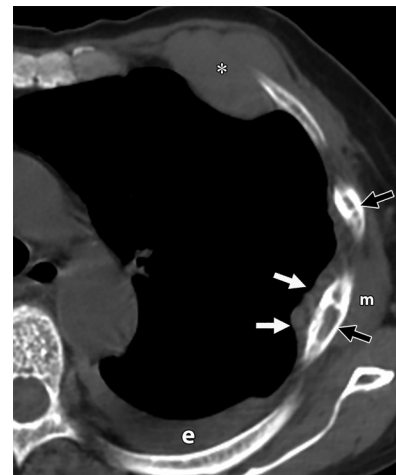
Multiple myeloma. Axial cropped CT image shows a large soft-tissue mass (*) involving the EPS and intercostal plane, multiple tumoral nodules (white arrows) in the EPS, and a mass (m) in the right chest wall. Pleural effusion (e) and lytic bone lesions (black arrows) in the ribs also are seen.
